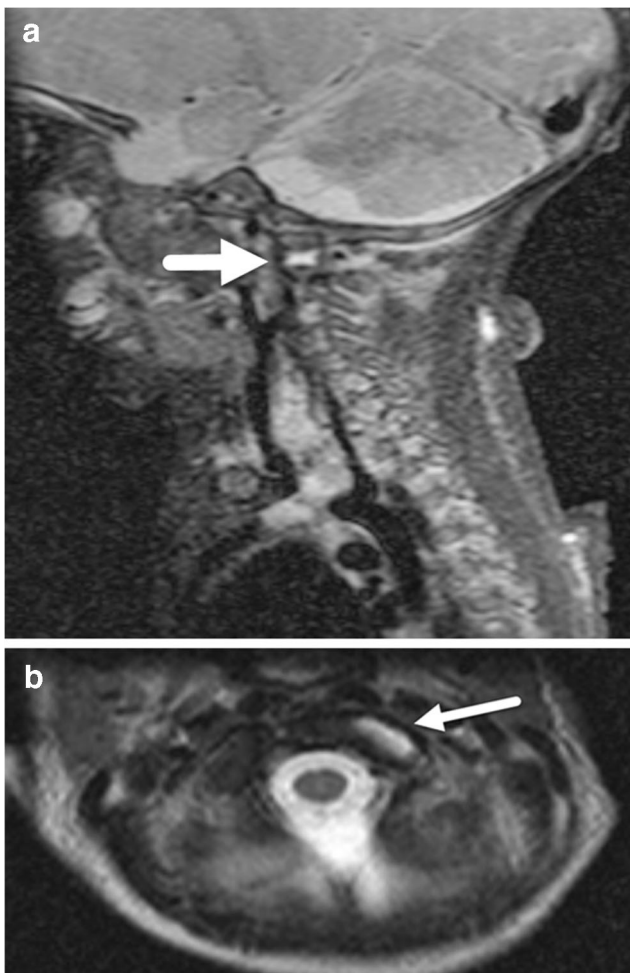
Capsular injury in a 4-month-old boy with abusive head trauma. a Sagittal short tau inversion recovery (STIR) MR image of the cervical spine demonstrates evidence of capsular injury (*arrow*) of the atlanto-axial joint on the left side. b Axial STIR of the cervical spine confirms the capsular injury findings (*arrow*)
